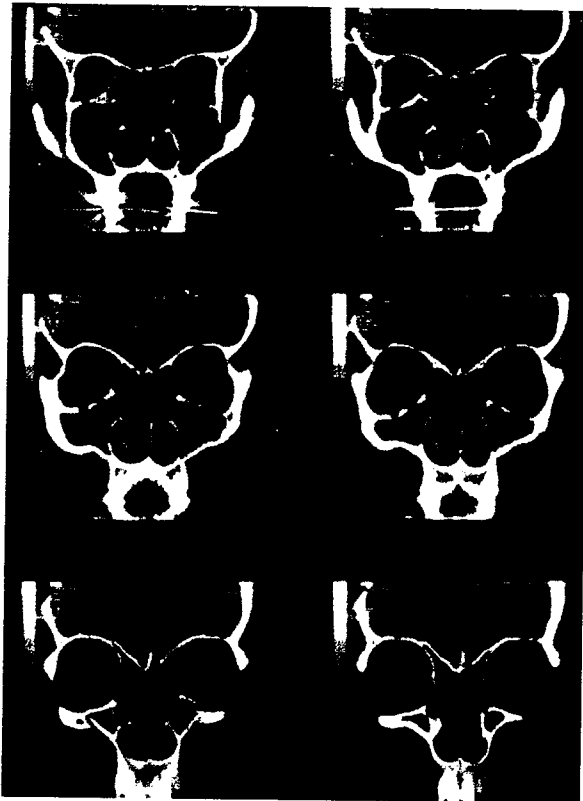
CT Sinus which shows pansinusitis.
